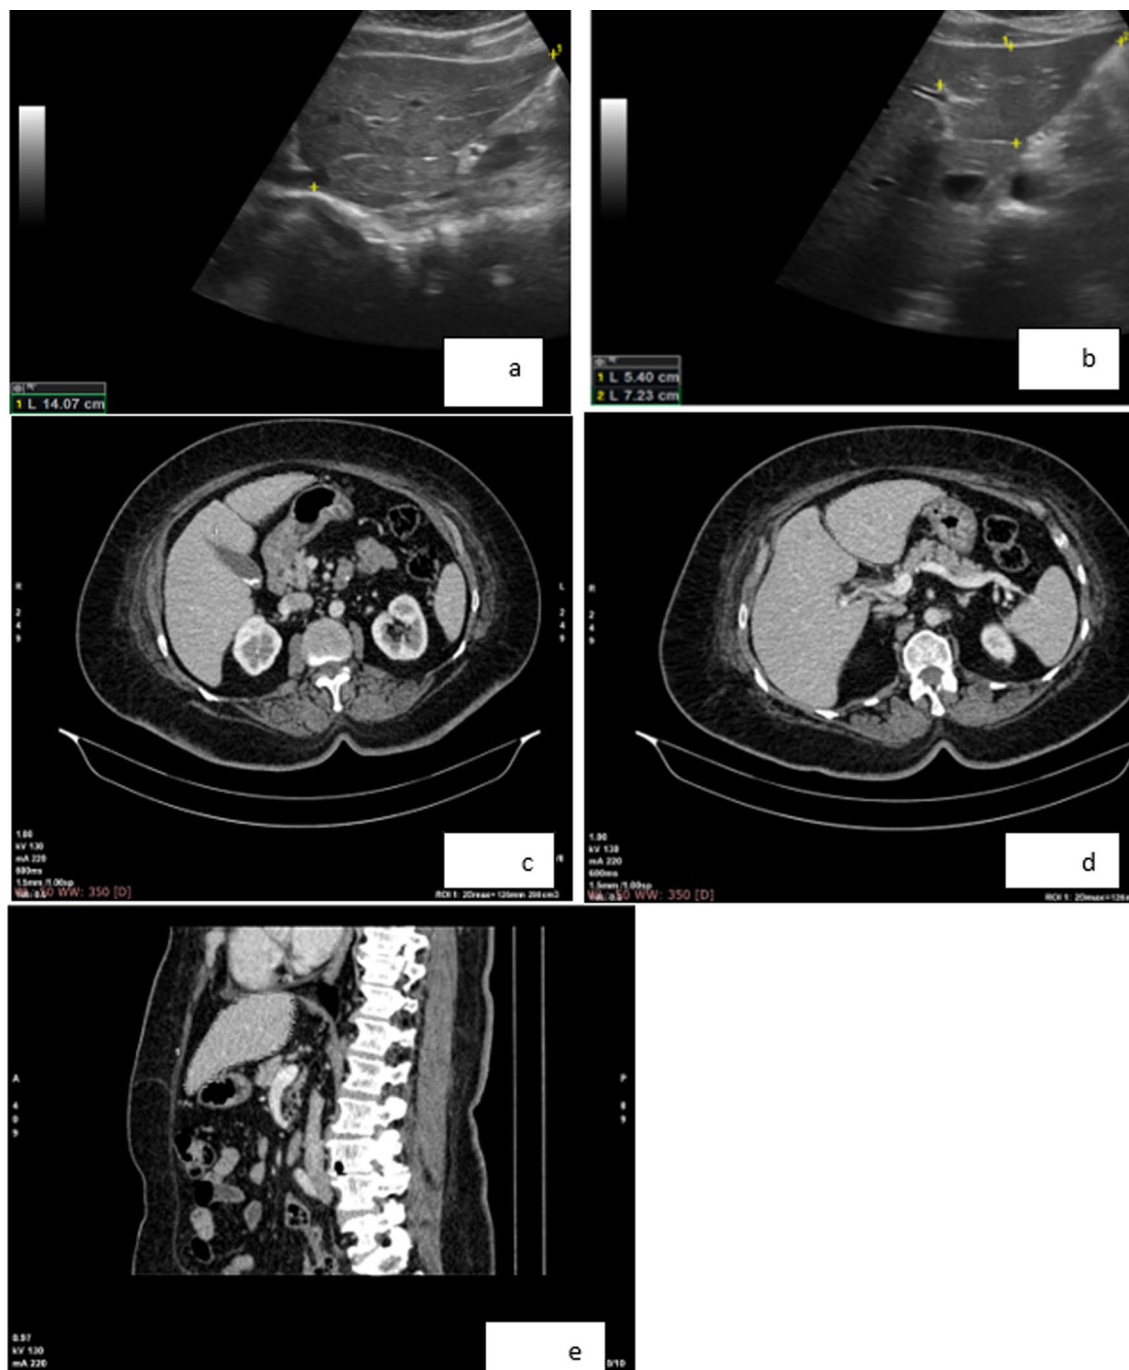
a–e US and CT images for 37 years old female with a history of diabetes and BMI=37.5. a and b US images measuring the height, length, and width with the estimated LHL volume by ultrasound = 285 cm³. c and d axial CECT images and e sagittal CECT image estimating the LHL volume = 290 cm³
